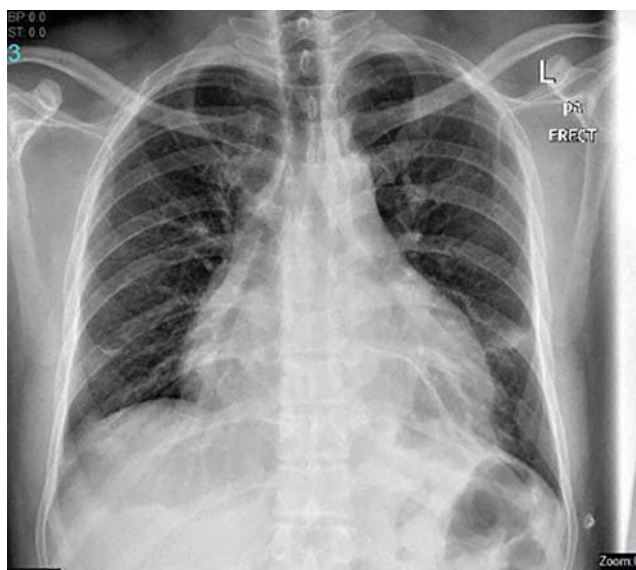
Chest X-ray before discharge shows good resolution of the bilateral pleural effusion and pulmonary infiltrates.
